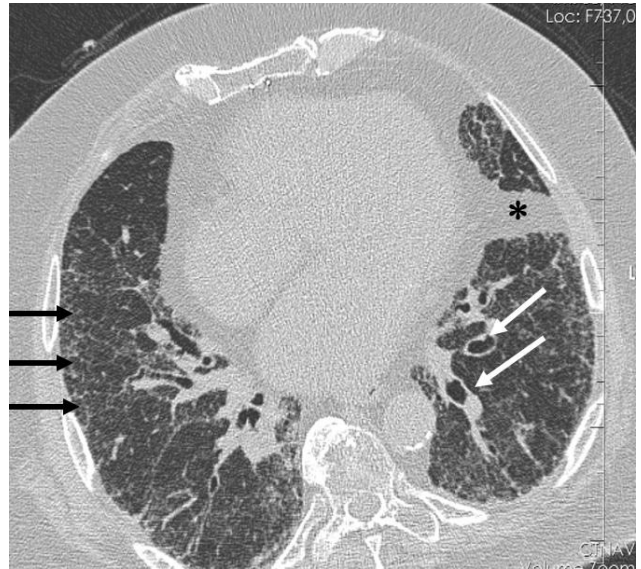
A 49-year-old female ex-smoker with a normal PFT. Axial contrast-enhanced thorax CT image shows bronchial wall thickening and bronchiectasis in the left lung (white arrows). Note the dominantly peripheral interlobular septal thickening in bilateral lungs (black arrows) and subsegmental atelectasis (asterisk).
